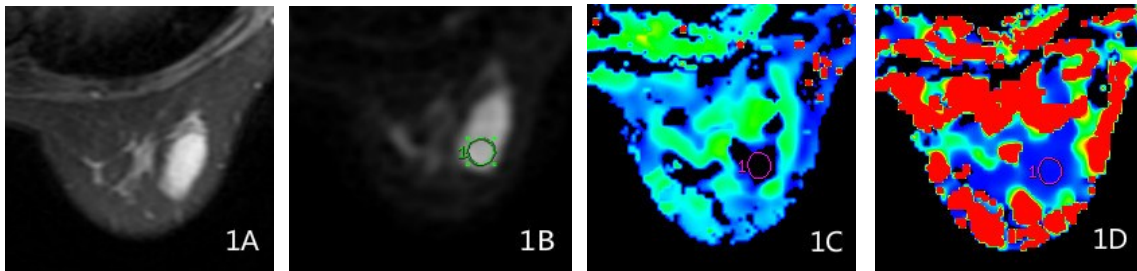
The images of MRI scanning for patients with grade I breast cancer. Thirty-eight years old female patients with right breast invasive cancer at grade I. (1A) T2WI sequence of fat suppression. (1B) The corresponding gray-scale image when selecting ROI. (1C, 1D) The IVIM parameters of this patient: $D\text{-mono} = 0.00423$; $D^*\text{-mono} = 0.00105$; $f\text{-mono} = 0.26335$; $D\text{-bi} = 0.00121$; $D^*\text{-bi} = 0.00711$; $f\text{-bi} = 0.27714$. f , perfusion fraction; D , pure diffusion coefficient, D^* , pure diffusion coefficient.
